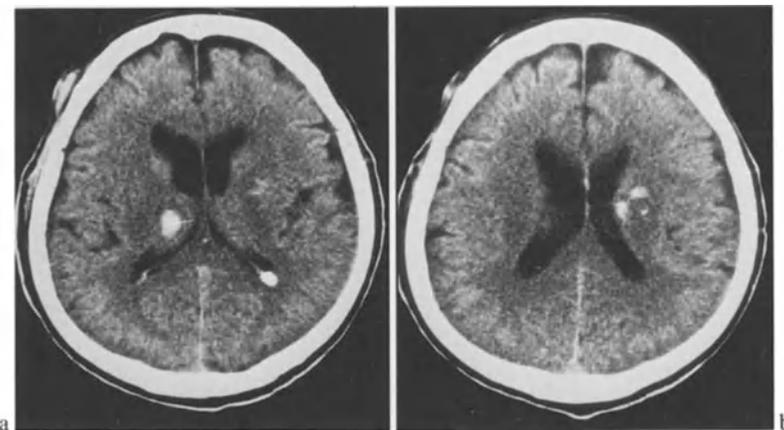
a, b. CT scans on day of accident in a 66-year-old male with bilateral contusions in the basal ganglia. The patient survived in a vegetative state
